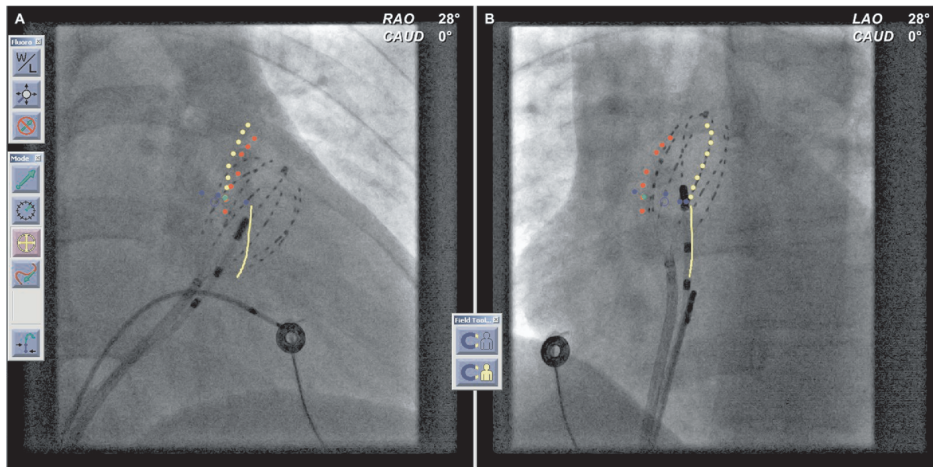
Navigant screen showing the two radiographic views obtained (right anterior oblique [RAO] on the left, left anterior oblique [LAO] on the right). The basket catheter with its eight splines can be seen within the right ventricular outflow tract with a temporary bipolar ventricular pacing lead. The magnetically enabled catheter has been navigated to a more anteroposterior position on the horizontal line of blue dots (previous mapping positions). Two of the splines have been marked on the Navigant software (yellow and red dots). The effect of respiration on the image acquisition can be seen in the RAO radiographic field. The yellow line indicates a virtual catheter drawn where the software identifies the catheter should be located according to the applied magnetic field.
